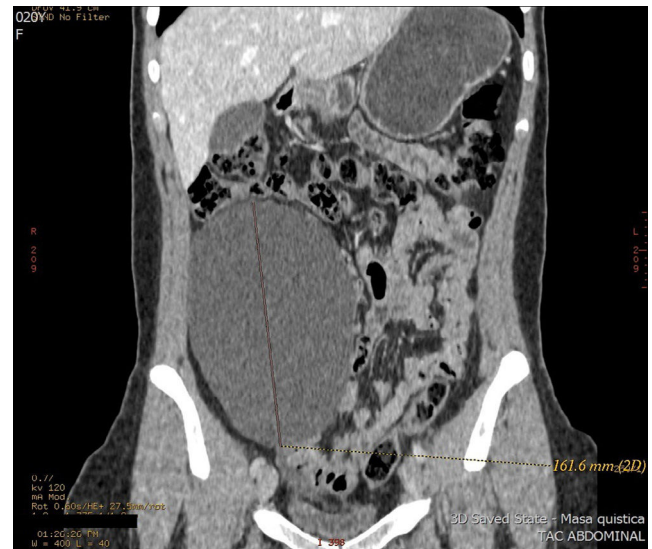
Computed tomography scan showing the retroperitoneal cystic mass in the right anterior renal region measuring 16 cm×12 cm×6 cm, with homogenous density.
